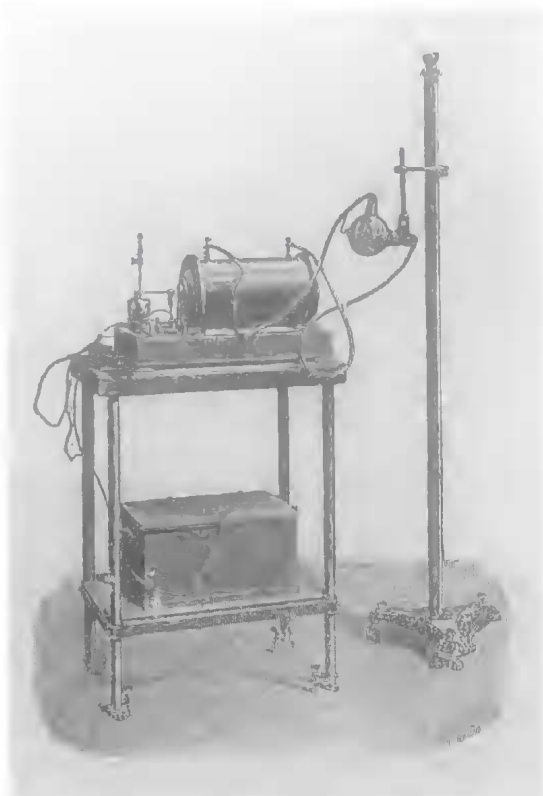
Early X-ray machine used in Queensland. Prior to 1901 more than fifty of this type had been sold in the state, an indication of the ready acceptance of the discovery.
